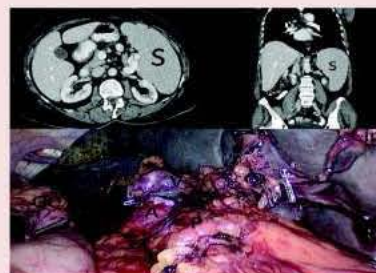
CT images of splenomegaly due to marginal zone lymphoma. GC:greater curve of stomach, A:splenic artery, P:tail of pancreas, V:splenic vein, ip:inferior pole of spleen)
